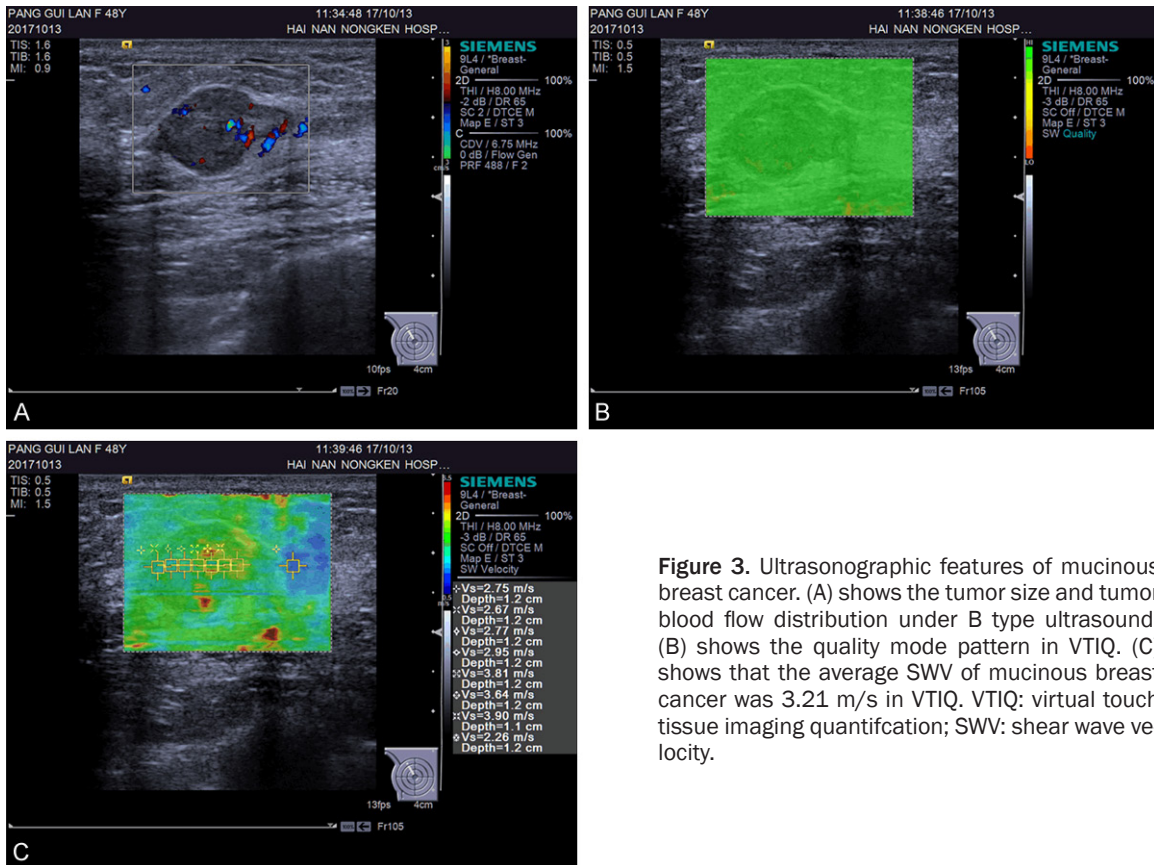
Ultrasonographic features of mucinous breast cancer. (A) shows the tumor size and tumor blood flow distribution under B type ultrasound. (B) shows the quality mode pattern in VTIQ. (C) shows that the average SWV of mucinous breast cancer was 3.21 m/s in VTIQ. VTIQ: virtual touch tissue imaging quantification; SWV: shear wave velocity.
